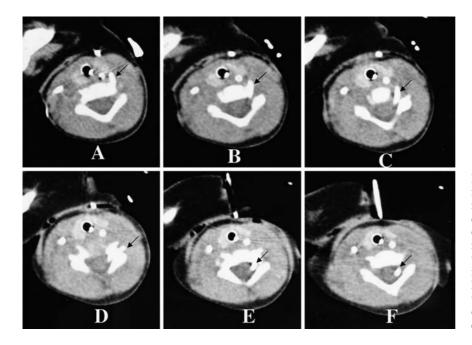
Computed tomography scanning of the neck. The left side of each image is the anatomic right. A The catheter is observed in a location where it may enter the foramen. B–D The catheter is imaged where it enters the C6-C7 intervertebral foramen and approaches the intrathecal space. E and F The catheter has migrated into the left lateral intrathecal space. No deformation of the cord or hematoma is observed. *Arrows* show catheter positions
